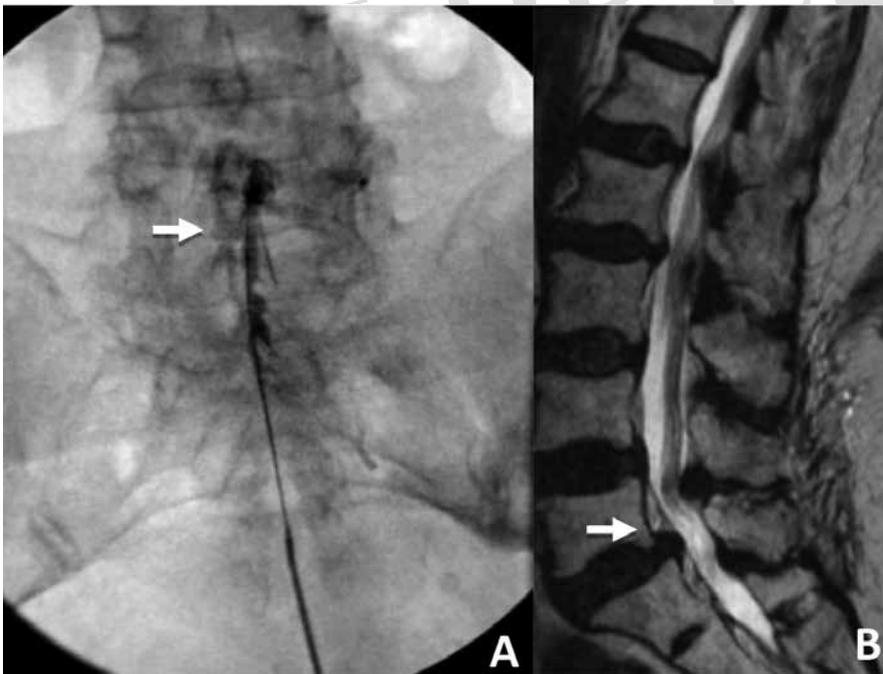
(A) Intraoperative imaging depicting epidural contrast medium spread in the lumbar spine after caudal injection. (B) T2-weighted MRI imaging of the lumbar spine in the sagittal plane after caudal injection demonstrating no evidence of an epidural collection.
